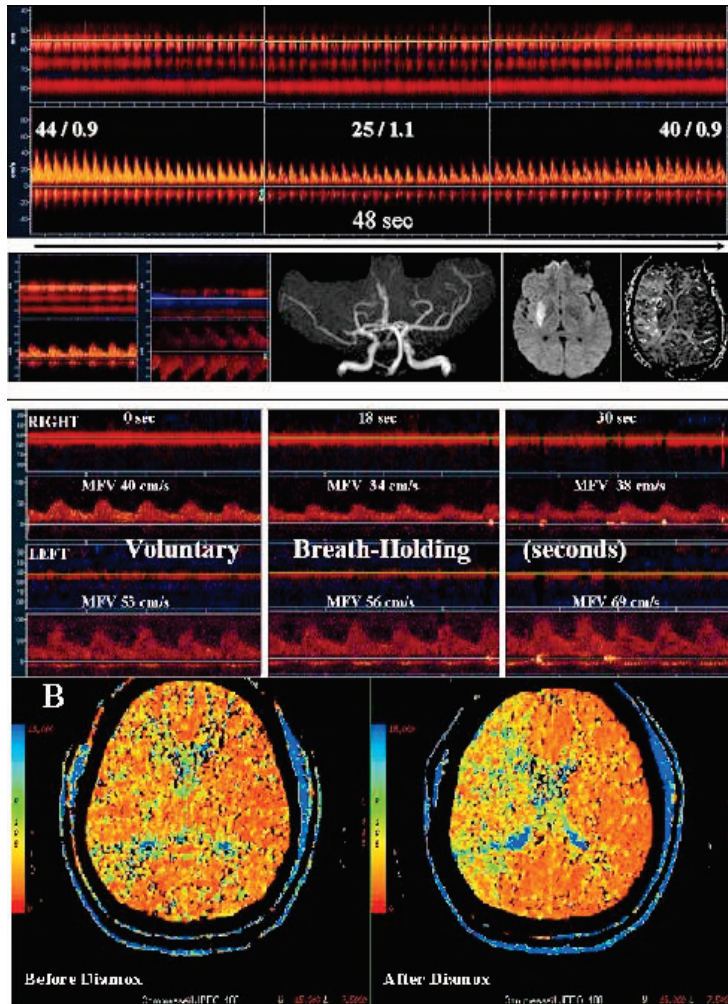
A. Spontaneous velocity fluctuation with thrombolysis in brain ischemia (TIBI) 3 residual flow with embolic occlusion (MRA insert) and diffusion-perfusion mismatch (MRI insert). Bottom left, Thrombolysis in brain ischemia (TIBI) grade 3 waveform and flow diversion. Steal magnitude= $[(25 \text{ cm/sec}-44 \text{ cm/s})/44 \text{ cm/sec}] \times 100 = -43.2\%$. B. Bilateral MCA monitoring during BHI with a proximal internal carotid artery occlusion. Affected MCA MFV decreased at 18 s (middle frame). The steal magnitude was $[(34 \text{ cm/s}-40 \text{ cm/s})/40 \text{ cm/s}] \times 100 = -15.0\%$. Increased flow on left nonischemic hemisphere and decreased right MCA flow indicating vasoparalysis on CT perfusion after Diamox. In this situation the pressure gradient within leptomeningeal collaterals may decrease and manifest as a deterioration of the patient's neurological status.
